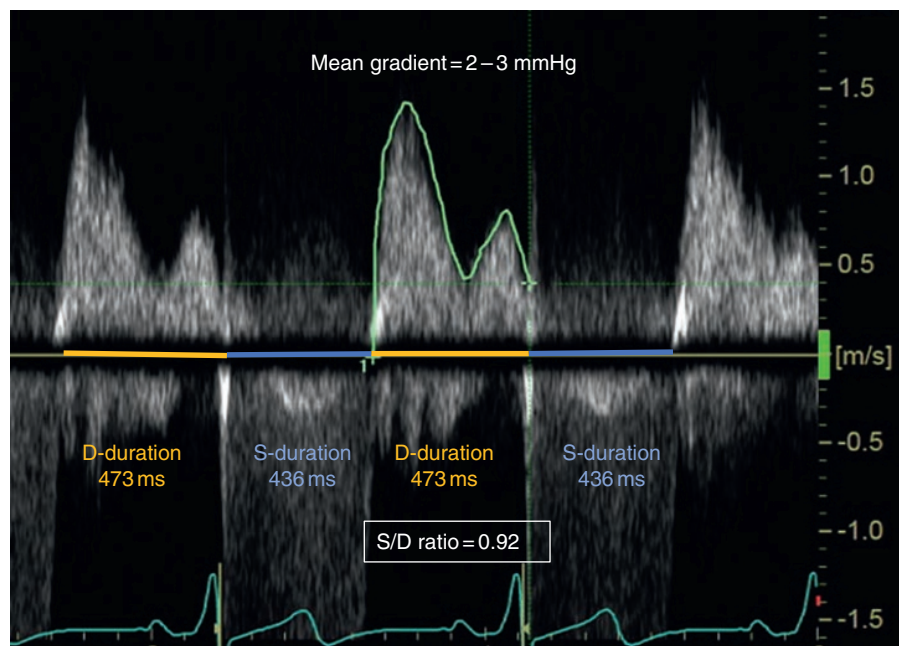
Assessment of S/D ratio. A continuous-wave Doppler tracing is obtained through the tricuspid valve inflow capturing the regurgitant jet. Systolic duration is measured from the duration of the tricuspid jet (blue color line). Diastolic duration is measured from the tricuspid inflow (yellow color line). The S/D ratio is calculated and was found to be normal in this patient. With progressive dysfunction, typically systolic duration increases and diastolic duration decreases, resulting in an increased S/D ratio.
